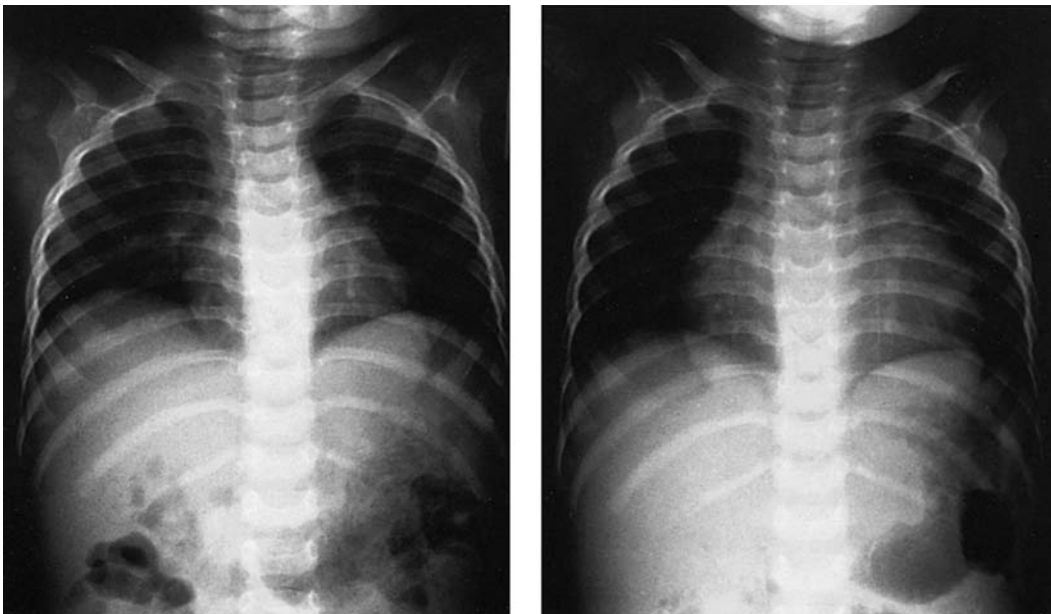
Radiographs from an infant 4 days before and at the time of the diagnosis of purulent pericarditis. Note the increasing heart size and the “water-bottle” silhouette.
